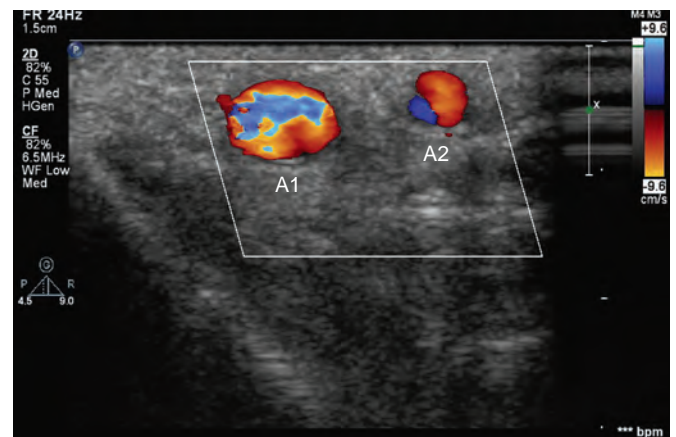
A typical ultrasound image with color Doppler during short-axis (transverse) cannulation. Note the anatomic variation with a larger radial artery (A1) next to a smaller artery (A2) positioned laterally.
